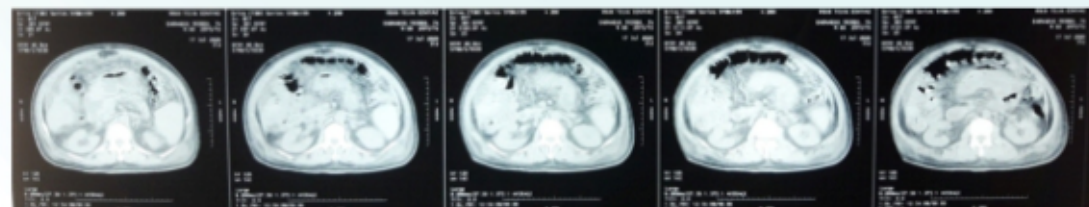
CT-SCAN no apparent intraabdominal mass, collection of intraabdominal fluid
